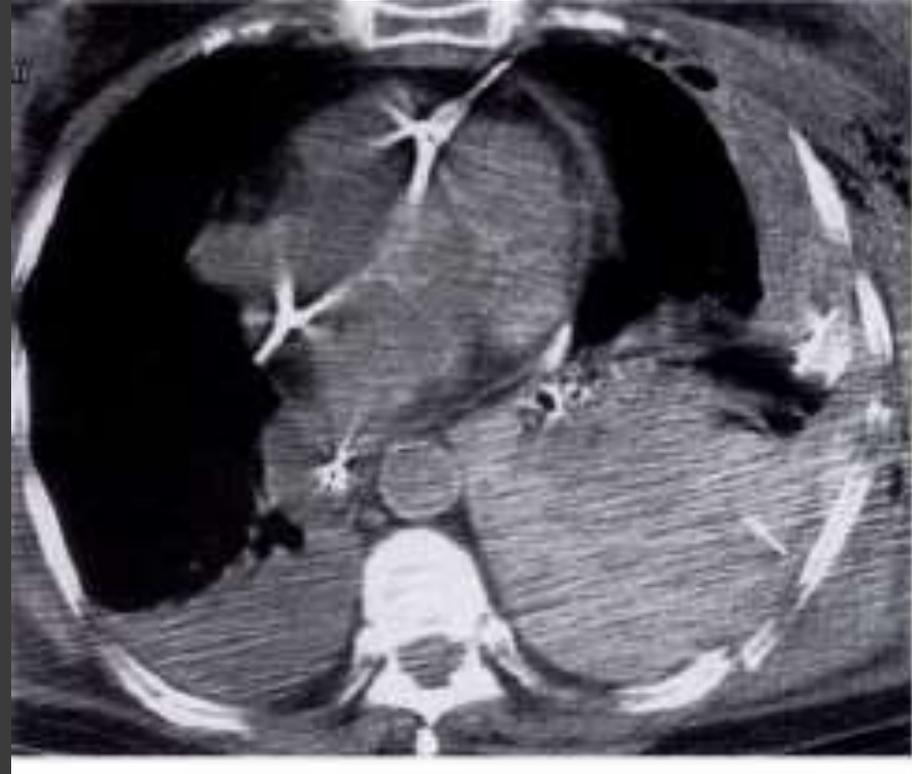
Burst fracture of a thoracic vertebral body in a 21-year-old man injured in a high-speed motor vehicle accident. (a) CT scan demonstrates a burst fracture of T10 and obliteration of the spinal canal by bone fragments. Pneumomediastinum and bilateral pleural effusions are also present. (b) CT scan obtained at a higher level reveals an unsuspected sternal fracture (arrow).
